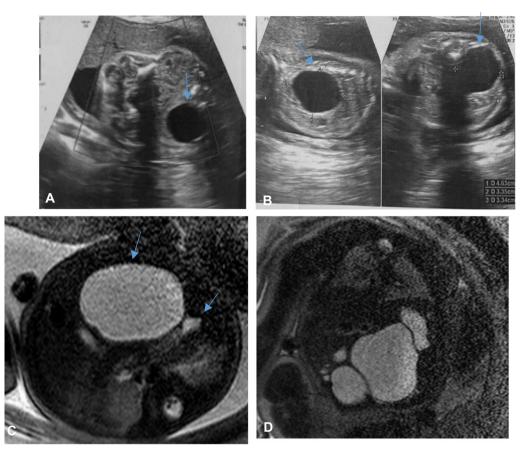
A 33-year-old pregnant female with antenatal US showing a well-defined cystic structure in the fetal abdomen in the early 3rd trimester. Ultrasound findings: A, B Axial, sagittal, and axial sections of the fetal abdomen show well-defined hypochoic cystic lesion at the right hypochondrium. MRI findings: US C axial T2WI, D coronal T2WI of fetal abdomen and pelvis revealed a well-defined cystic structure located in the right hypochondriacal and lumbar space with fluid signals within, compressing and displacing the stomach to the left side and abutting the visceral surface of the liver. MRI excluded its communication with the Gall bladder and surrounding bowel loops. Combined US and MRI Diagnosis: Large fetal mesenteric cyst. Termination by vaginal delivery at GA 39 weeks
